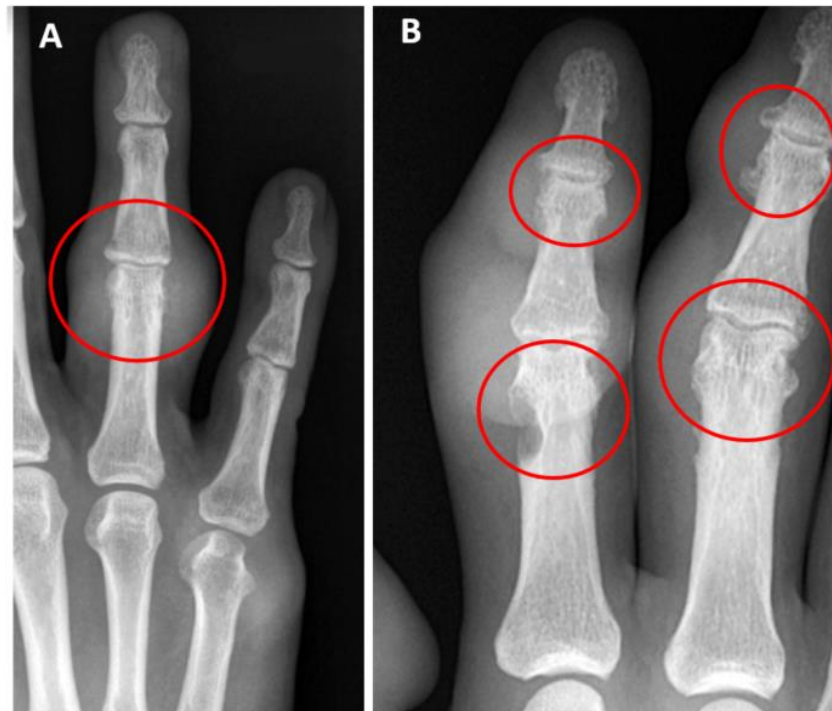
Dorsopalmar radiographs.
